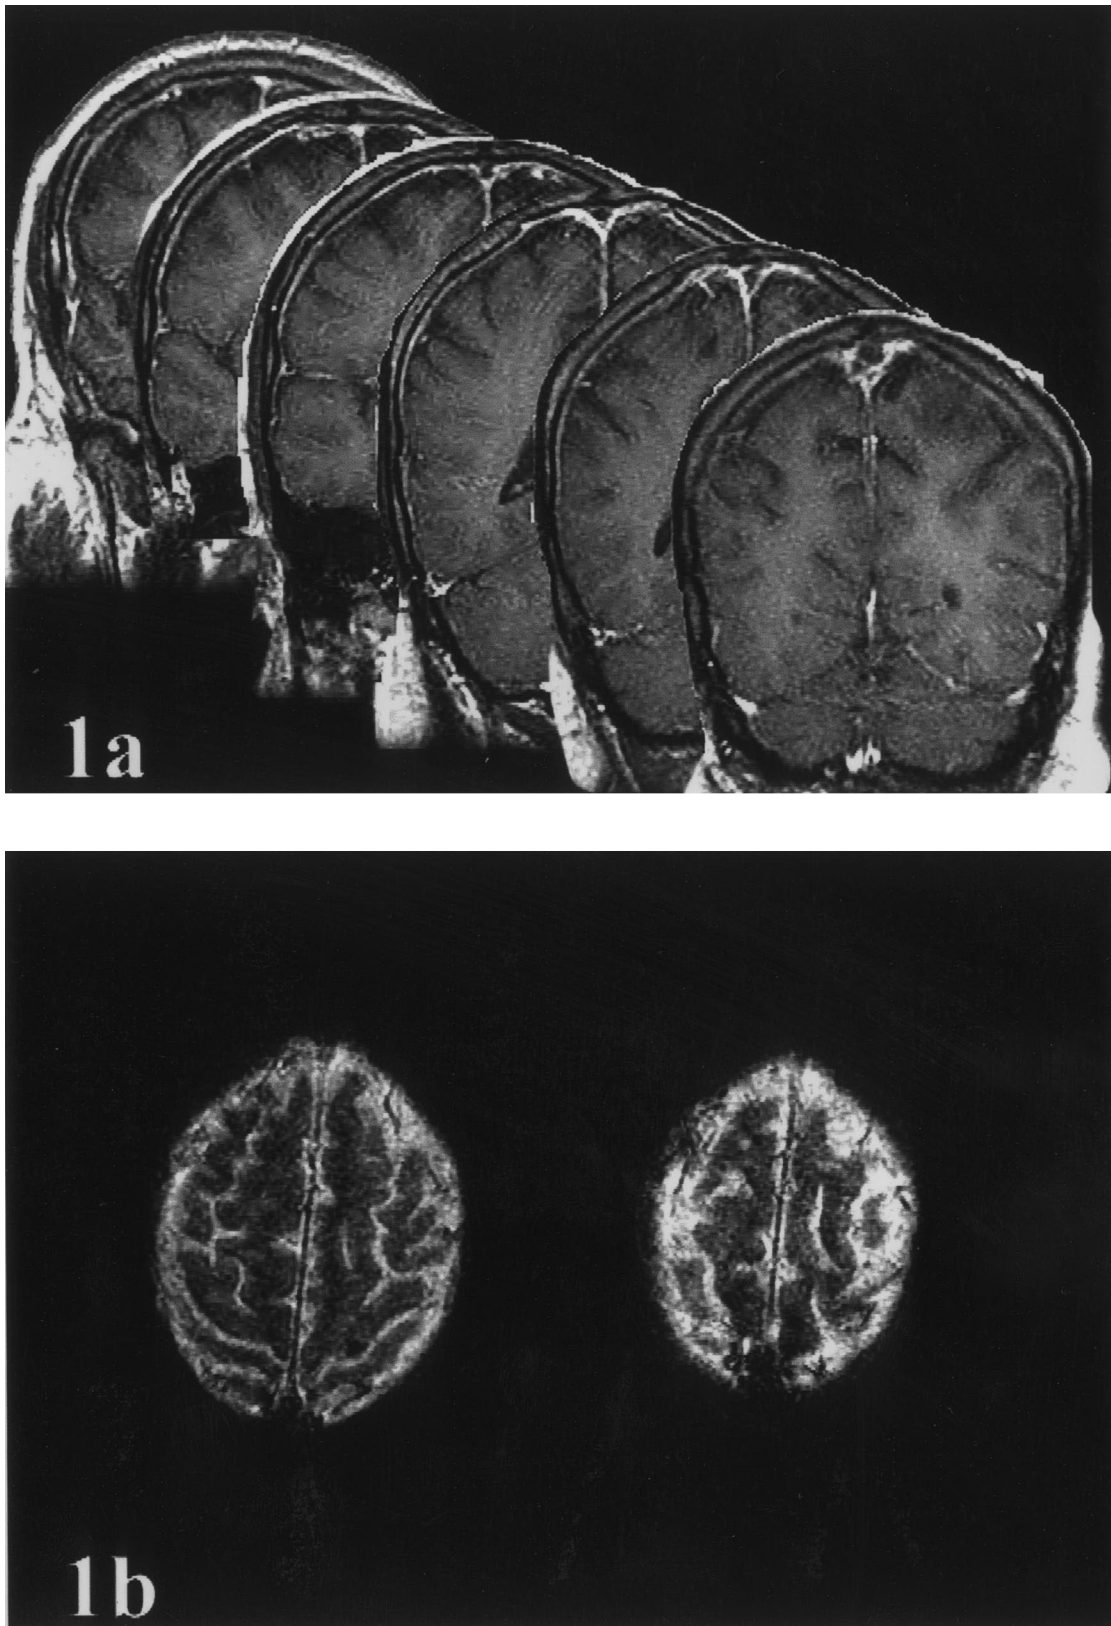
MRI findings: (a) Gadolinium-enhanced coronal T-1 images, arranged postero-anteriorly, showing filling defects in the superior sagittal sinus compatible with thrombus. (b) Multi-planar gradient echo (MPGR) images, showing areas of increased susceptibility in the high parasagittal region.
